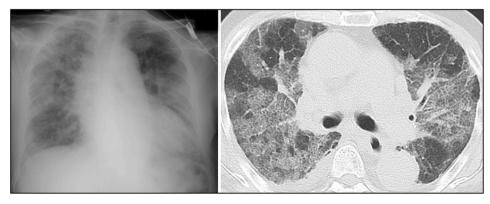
Chest radiograph and computed tomography scan showing bilateral patchy ground-glass opacities, infiltrative shadows, and pleural fluid.
